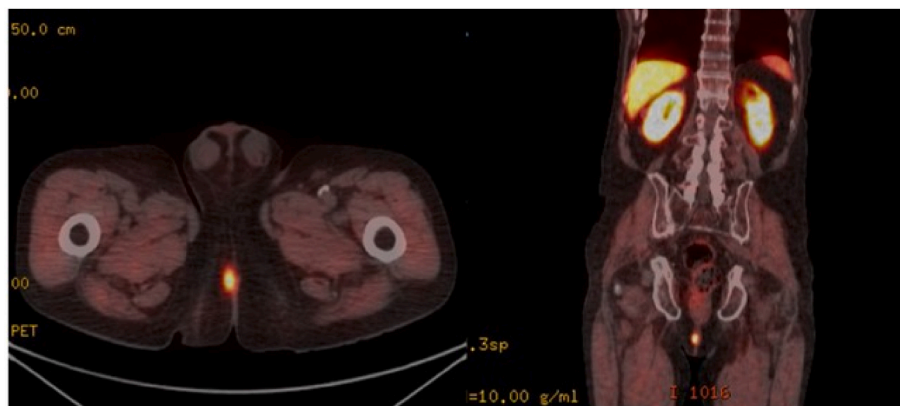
Fused ^{18}F -FCH PET-CT cross sectional imaging of in axial and coronal plane, showing hyper fixation of the tracer on a pseudo-nodular area in the cutaneous and subcutaneous tissues of the right paramedian perineum.
